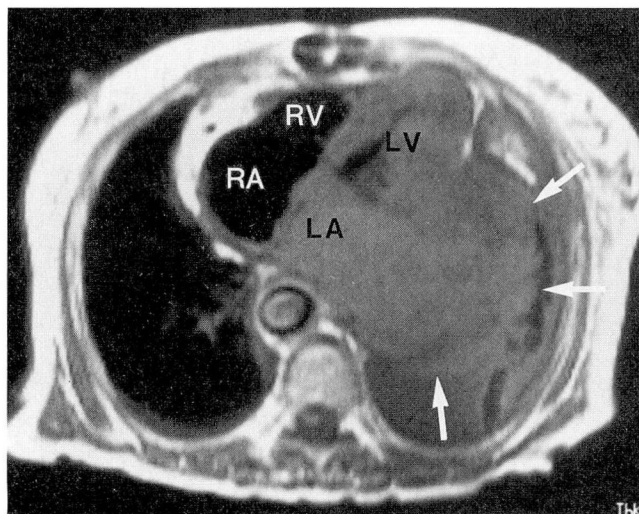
Magnetic resonance imaging of the heart (TR=728 msec, TE=22 msec) obtained 13 months after initial diagnosis demonstrated a tumor infiltrating the left atrium and left ventricle, extending through the pericardium into the left hemithorax (arrows). (RA, right atrium; LA, left atrium; RV, right ventricle; LV, left ventricle; TR, repetition time; TE, echo time.)
